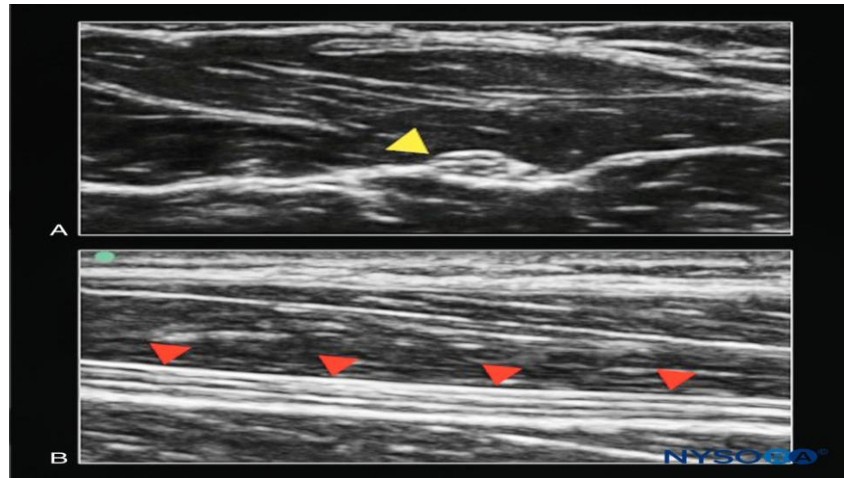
The median nerve. A: Cross-section (out of plane to ultrasound beam; yellow arrowhead). B: Longitudinal section (in plane to ultrasound beam; red arrowheads) (14)
